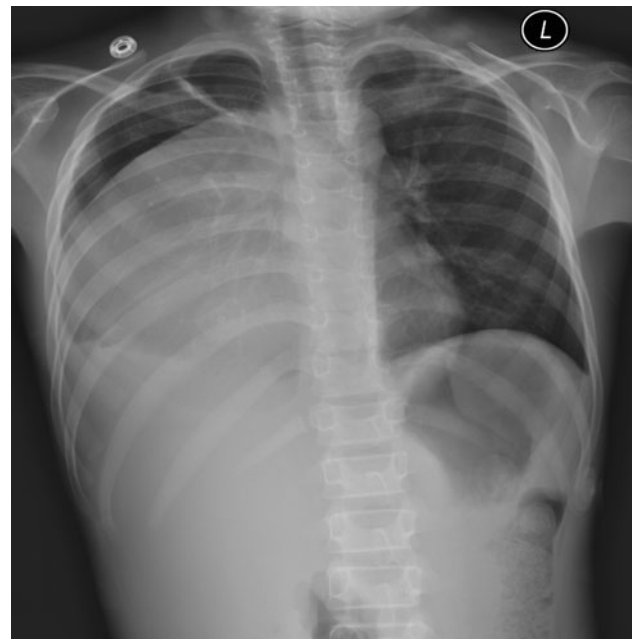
Anteroposterior chest *x-ray* showing a large right-sided chest mass
